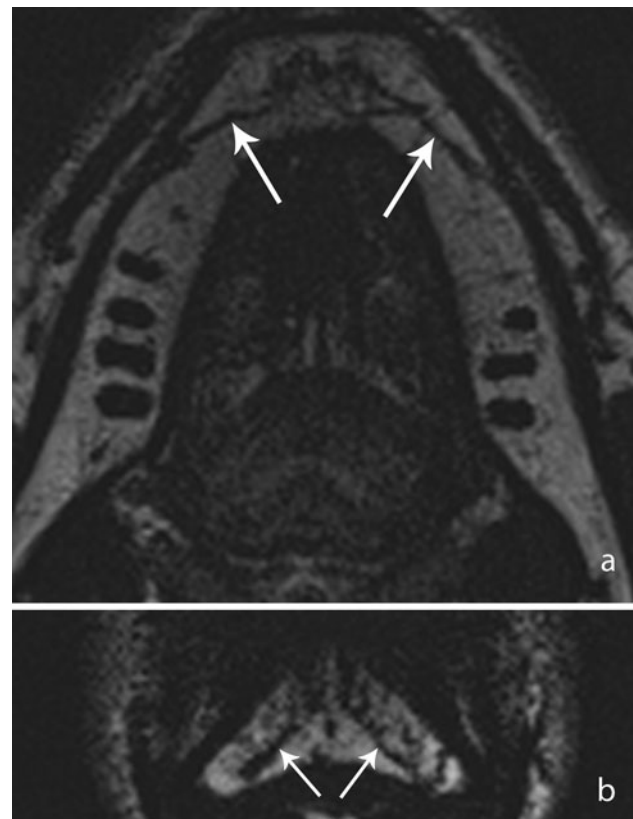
Axial (a) and coronal (b) T2-weighted MRI scans of the lower mandible. Clearly delineated incisive canal (*straight arrow*). Nutrient canals (*angular arrow*)
